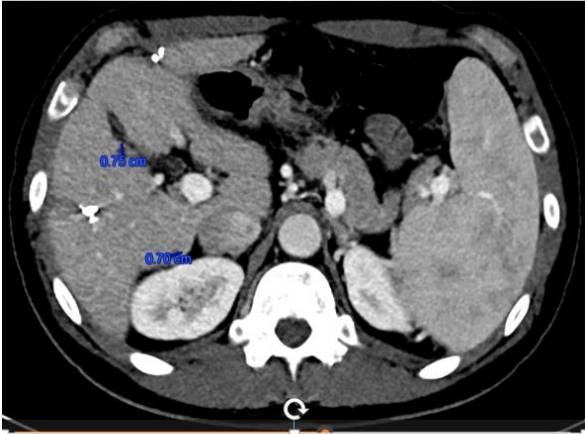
CT scan - Liver metastasis
